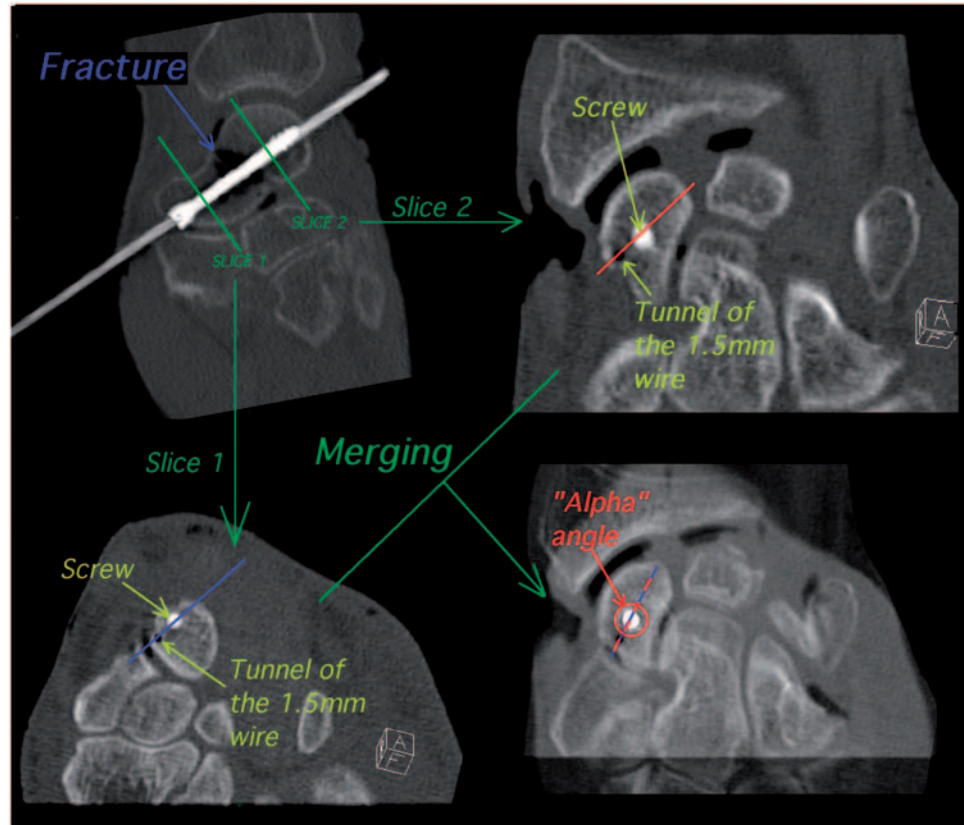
After screw insertion, two computed tomography slices were obtained, perpendicular to the screw and bone tunnel, above and below the fracture site. A line joining the centre of the screw and the tunnel of the 1.5 mm wire was drawn on both slices. Then, the two slices were merged, and the angle formed by the two lines (alpha angle) was measured. The angle was 0 in 21 cases.
